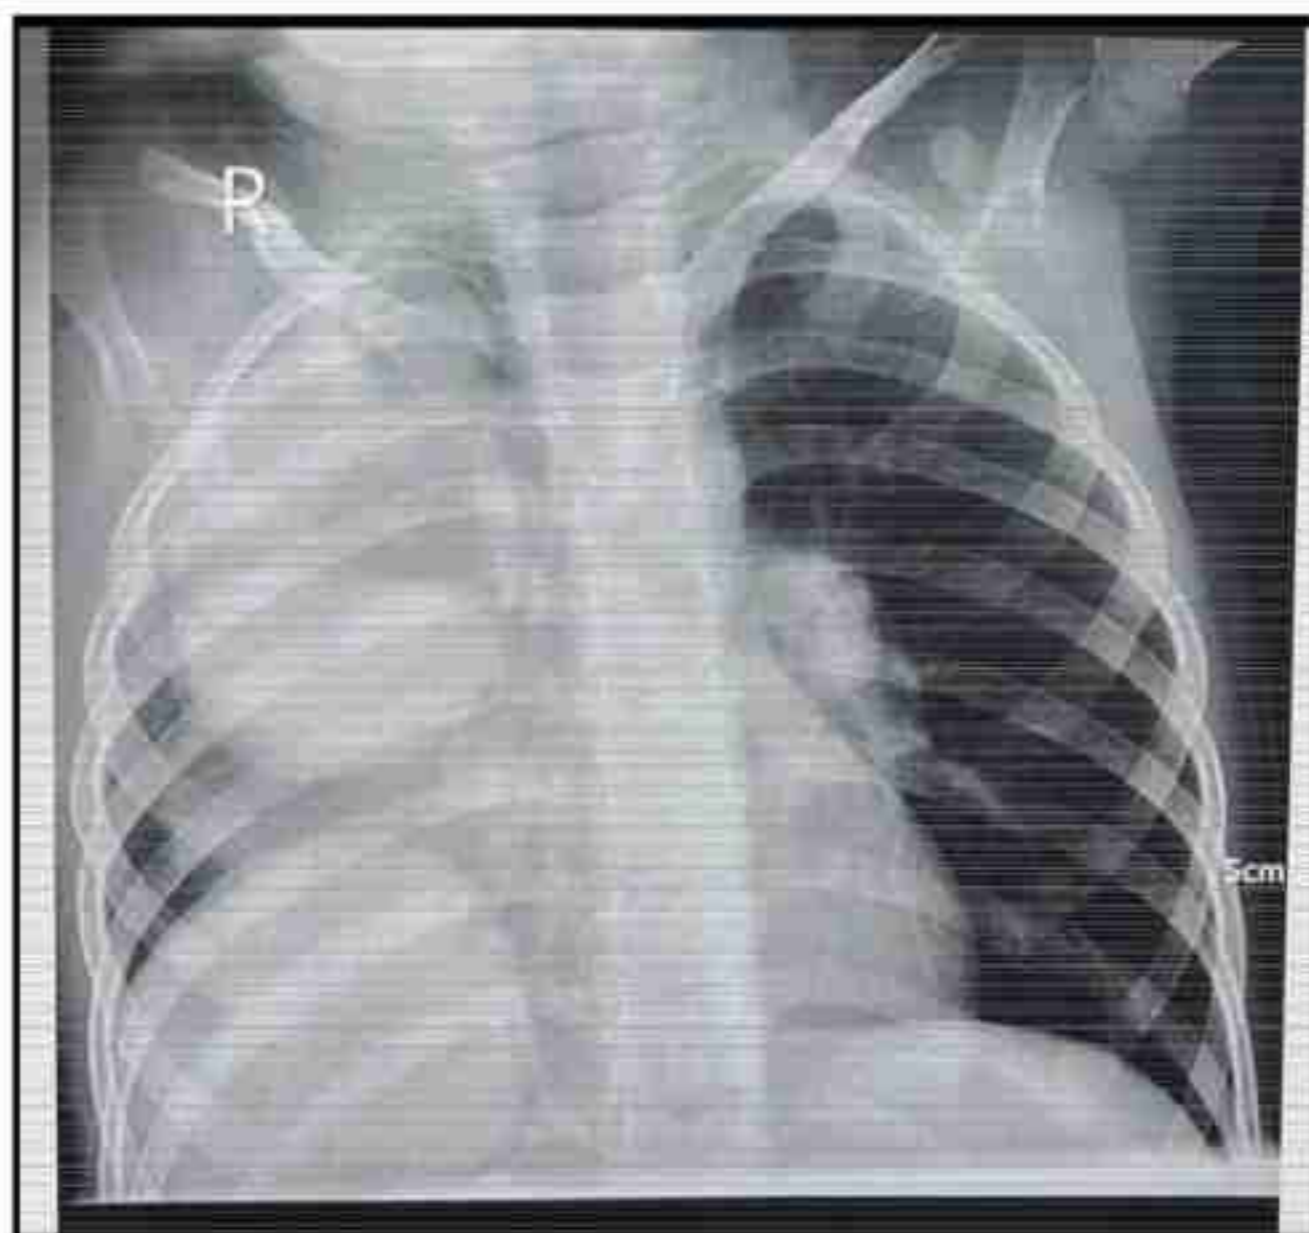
Chest X-ray showing a well-defined round opacity located in the lower zone and a cystic lesion with an air-fluid level in the middle zone of the right lung.
